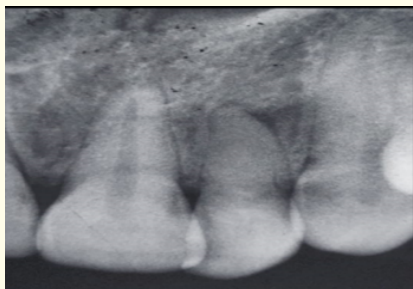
Preop radiograph of maxillary lateral incisor
